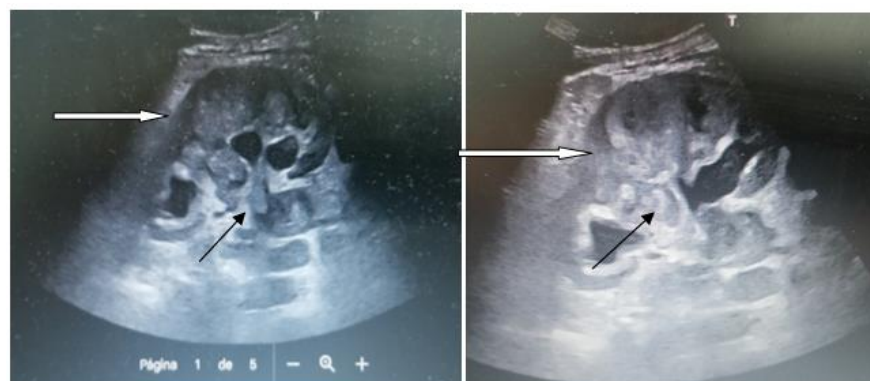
Renal ultrasound scan: LK (White arrow) showed signs of hydronephrosis with dense content in the urinary tract at the proximal pyeloureteral junction, of possible tumorous type (urothelioma) (black arrow)
